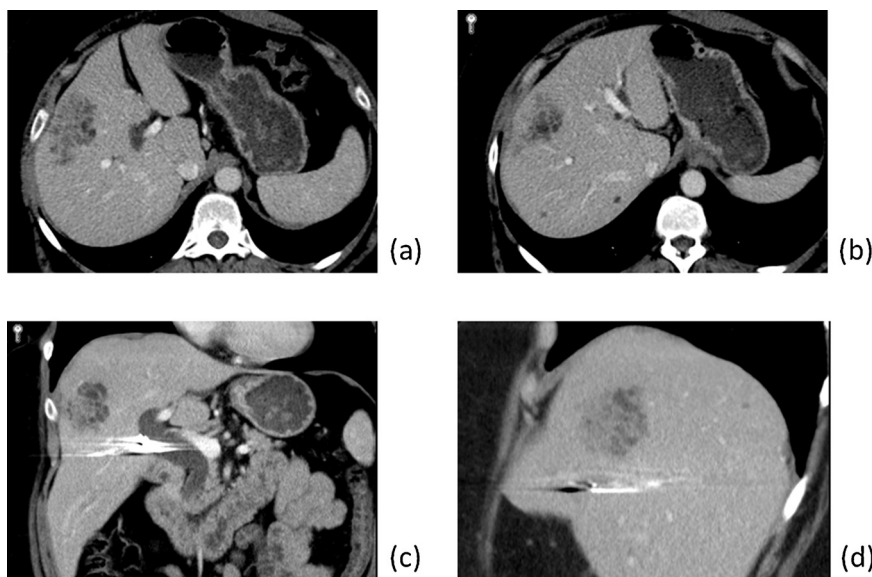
Axial (a and b), coronal (c) and sagittal (d) contrast-enhanced CT images through the liver demonstrate a 5.6 × 3.4 cm ill-defined lobulated mass located subcapsular in segment 8 of the liver. The lesion is predominantly composed of tubulocystic structures intermingled with strands of hepatic parenchyma. Two small additional microhamartomas are identified in segment 7 (b).
